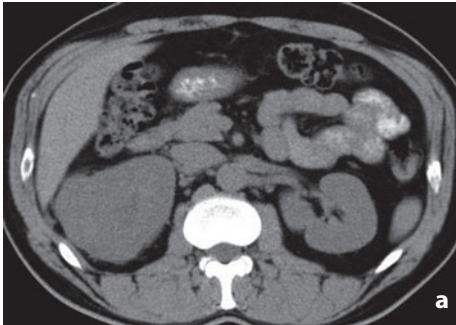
Computed tomography. Renal cell carcinoma. Contrast-enhanced dynamic study in the a baseline, b arterial, c venous and d delayed phase. Lesion located in the mid third of the right kidney
